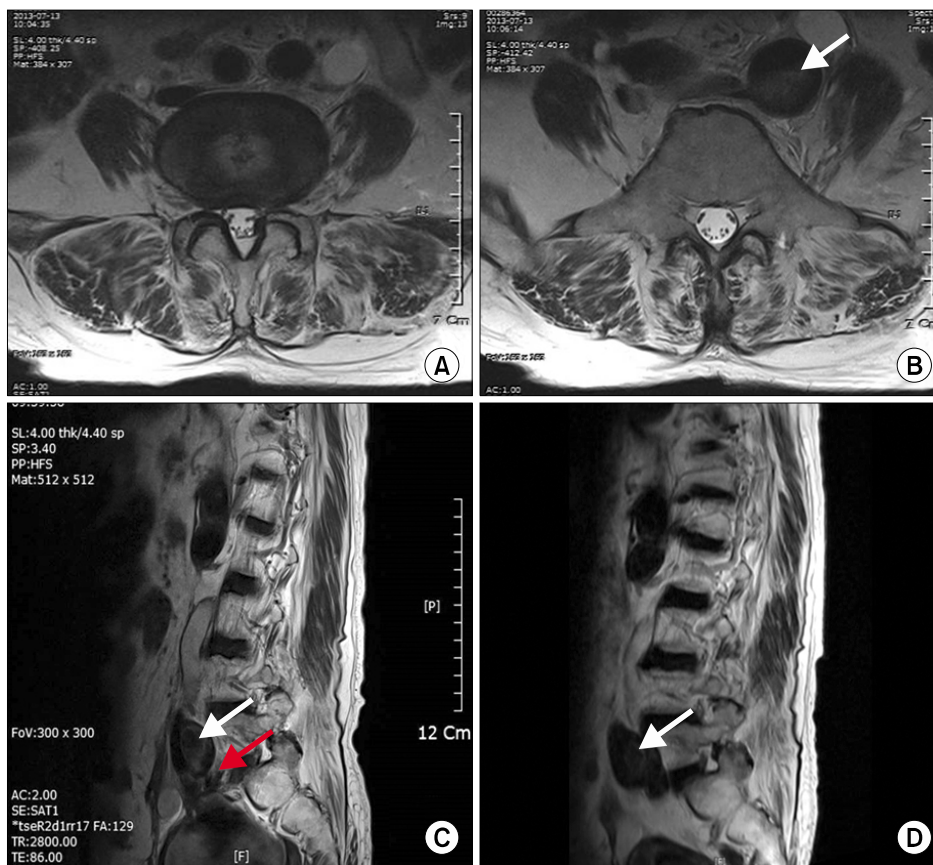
Non-contrast magnetic resonance imaging (MRI) of the lumbar spine. Axial T2-weighted images (A) show disc bulging and left foraminal and subarticular stenosis of L4-5. There is a large sized aneurysm with thrombus (white arrow) arising from left common iliac artery of L5 body level with irritating the surrounding lumbosacral plexus (red arrow) on axial (B) and sagittal (C) images. Thrombus inside of the aneurysm shows a tendency to grow compare to previous MRI (D) at the first-visit hospital.
